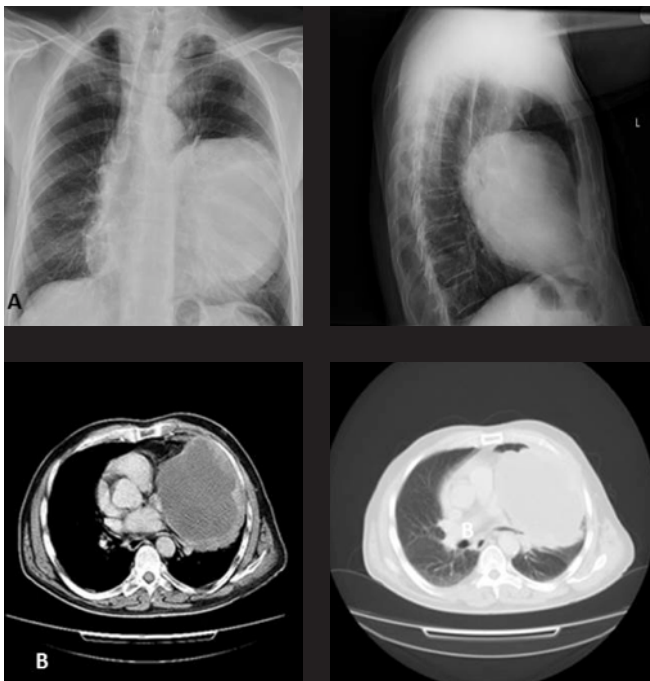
Chest x-ray at admission (A), thorax CT shows a homogeneously low attenuation lesion without enhancement (B).
